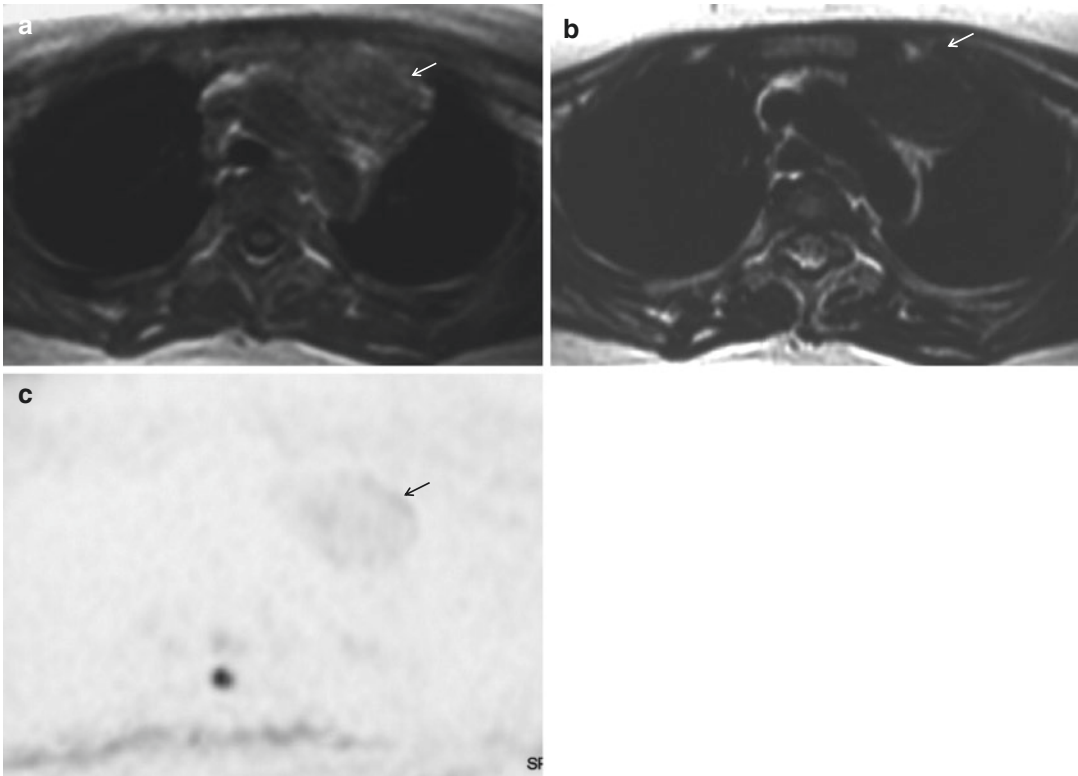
A residual mass of non-Hodgkin’s lymphoma after chemotherapy. T1-weighted (a) and T2-weighted (b) images show a well-demarcated mass of low signal intensity in the anterior mediastinum (arrow). (c) The mass does not show a
